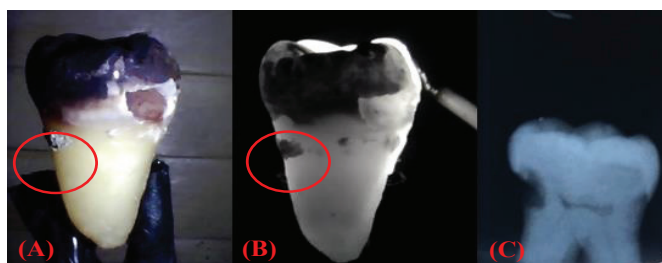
Sample 8 under visible light (A), NIR light (B), and X-rays (C).
